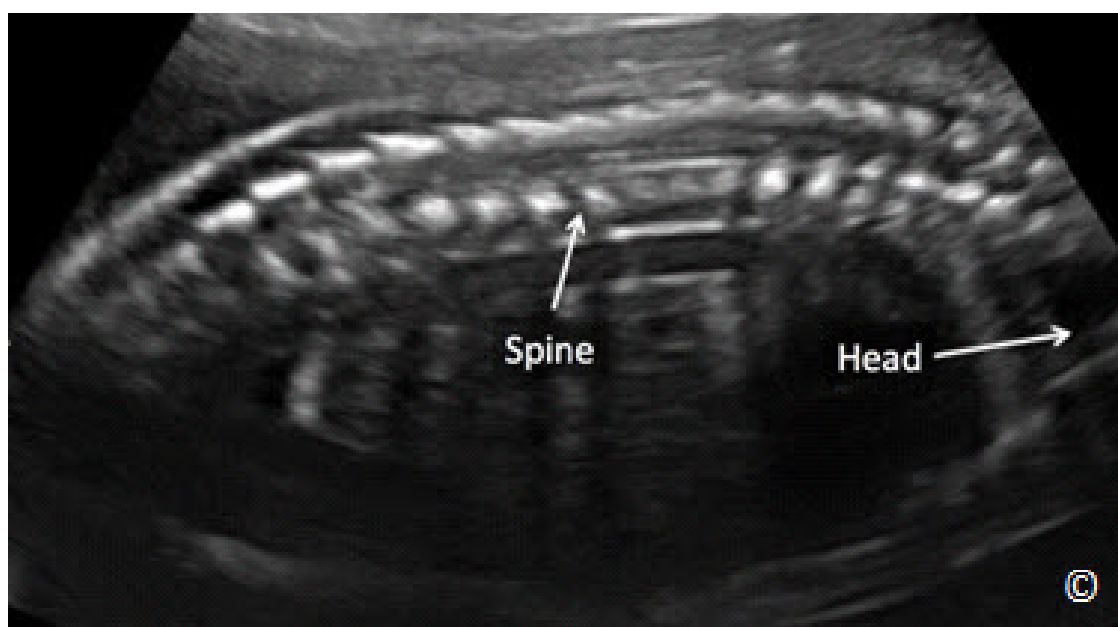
Mid-Sagittal view of the fetal spine (labeled) by ultrasound in the late second trimester of pregnancy. This plane is used to determine fetal lie in the uterus. The location of the fetal head is noted for orientation purposes. See text for details.
